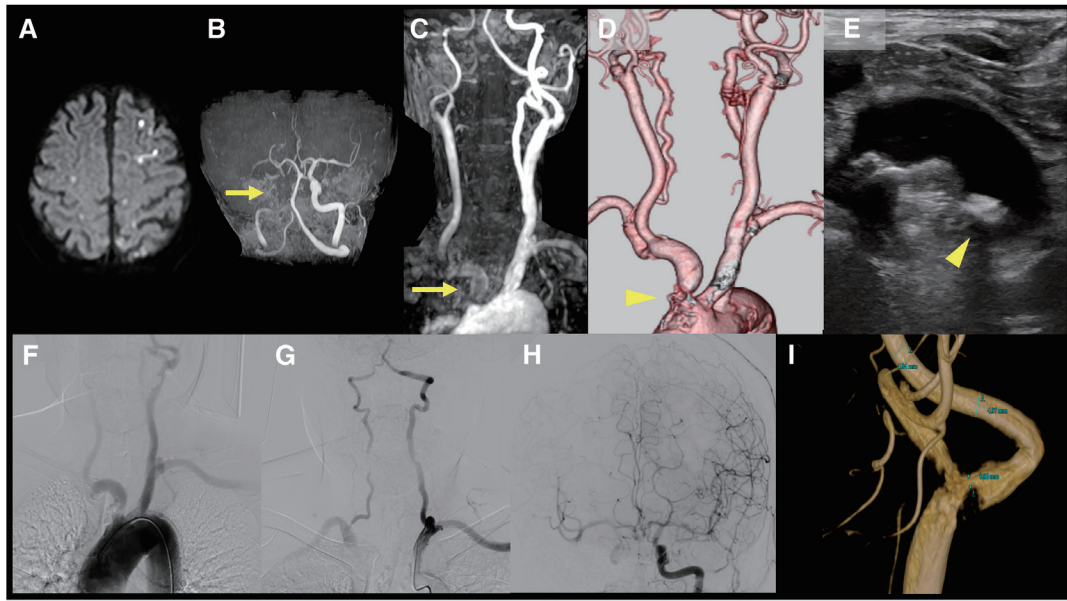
Imaging findings in case 1. (A) Diffusion-weighted MRI at admission. (B) Head MRA shows poor visualization of the right intracranial ICA (arrow). (C) Cervical MRA shows poor visualization of the innominate artery (arrow). (D) Severe stenosis at the innominate artery is shown in cervical CTA (arrowhead). (E) Ultrasonography shows a hyperechoic plaque at the innominate artery (arrowhead). (F) Aortic arch angiography. (G) Left subclavian angiography. (H) Intracranial view of left common carotid angiography. (I) 3D image of the cervical portion of the left common carotid angiography. ICA, internal carotid artery
